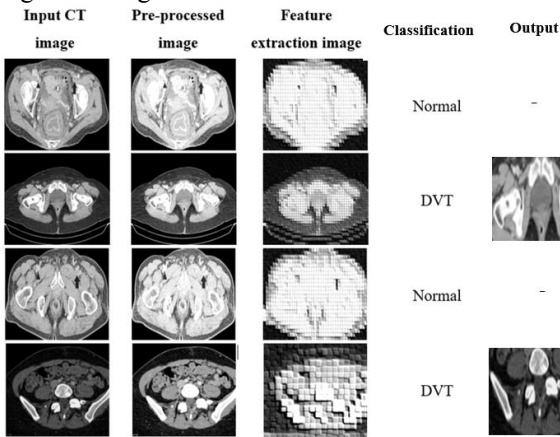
The experimental results of the proposed Deep Vein Net model using CT images.
